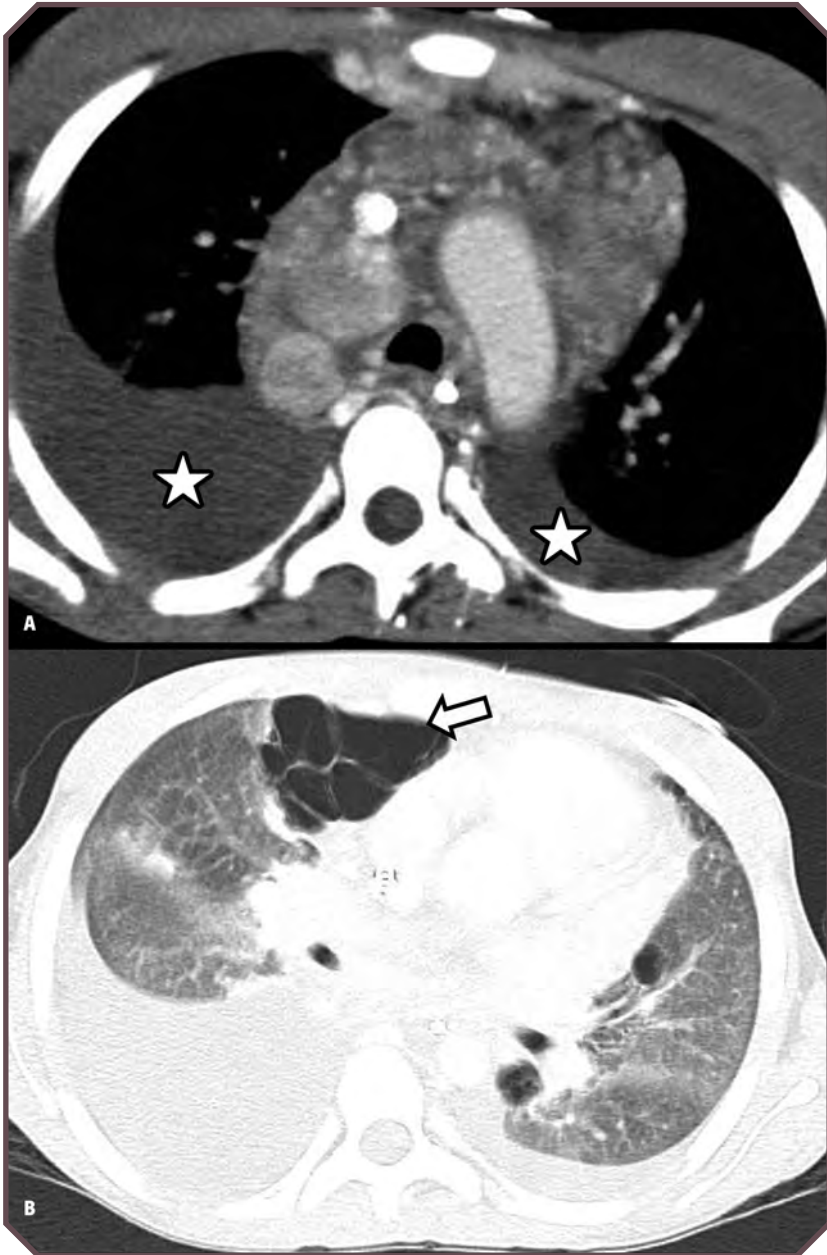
Chronic severe sarcoidosis in a 17-year-old girl. Axial contrast-enhanced computed tomographic images of the chest in A. soft-tissue and B. lung windows demonstrate mediastinal lymphadenopathy, bilateral pleural effusions (stars on A), diffuse reticulonodular interstitial markings, and extensive cystic changes (arrow on B).
